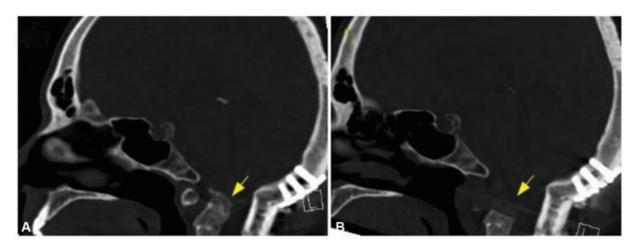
(A) Preoperative sagittal CT imaging demonstrates retropulsion of the odontoid process and basilar invagination. (B) Postoperative sagittal CT demonstrates removal of the anterior C1 arch and odontoid process resulting in brainstem decompression. CT, computed tomography.
